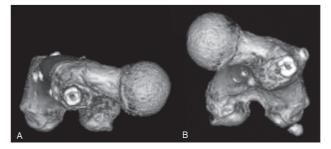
Case 2. A, Postoperative 3D CT of the left femur showing the femoral neck retroversion, which was the original rotation; B, Postoperative 3D CT of the right femur showing the femoral neck anteversion, caused by malreduction on rotation.
